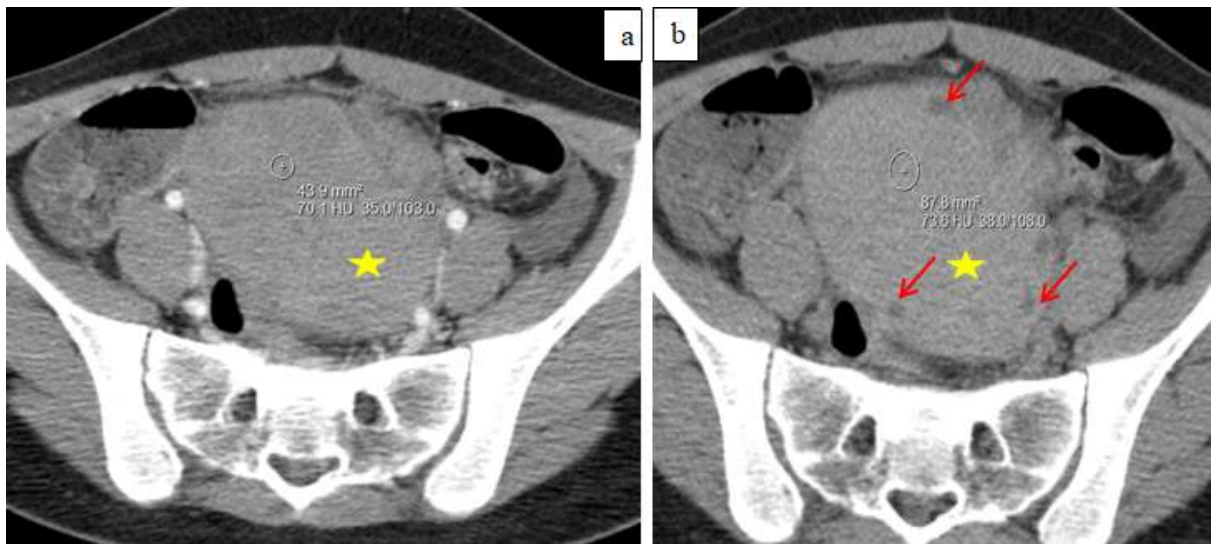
Pelvic c- (a) and injected (b) CT in axial section showing the edema of the ovarian parenchyma of high density (star), the peripheral arrangement of the ovarian follicles (arrow), and the absence of enhancement after injection.
